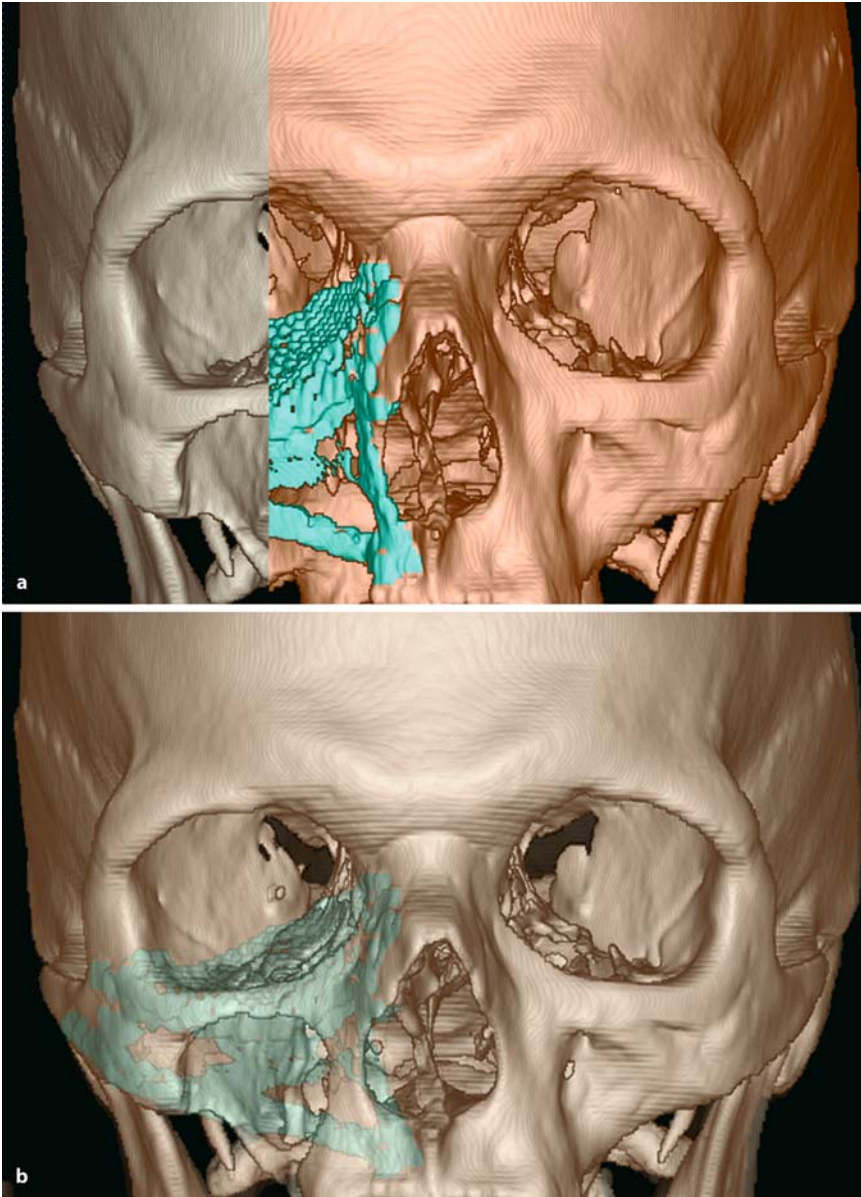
Image fusion for the postoperative evaluation of a partial midfacial resection. The 3D images represent a 50% fusion (a) and a complete fusion of pre- and post-operative CT data sets after the resection of a right maxillary sinus carcinoma (b). The resection was followed by a navigation-assisted primary reconstruction of the midface and orbit with titanium mesh
